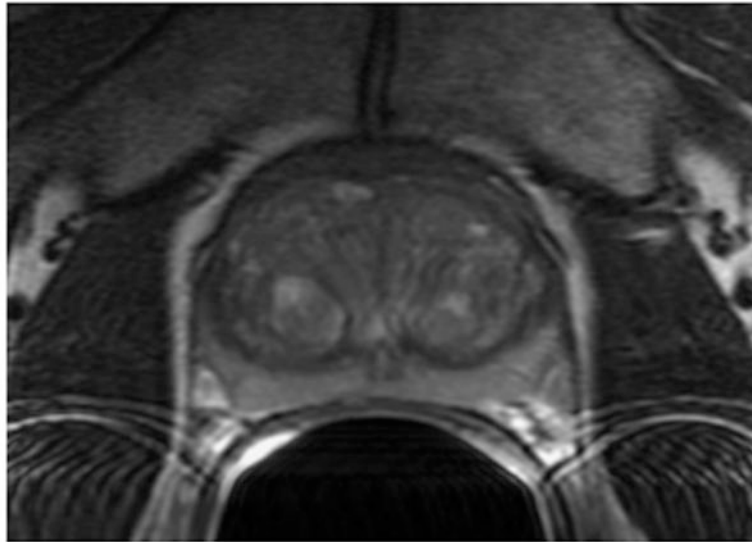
T2-weighted images of benign prostatic tissues for A) untreated patient with homogeneous tissue (age = 64.1 years, PSA= 2.14 ng/ml, Gleason 3+3), B) untreated patient with heterogeneous tissue (71.4 years, 5 ng/ml, G3+3), C) 5-ARI treated patient with homogeneous tissue (50.4 years, 4.44 ng/ml, G3+3).
